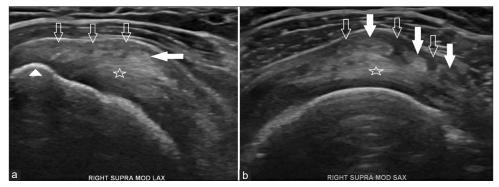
Ultrasound images of the right shoulder. (a) Long-axis and (b) short-axis sonographic images of the same right shoulder, demonstrating heterogeneity and enlargement of the supraspinatus (SUPRA) tendon (stars) with multiple nonshadowing amorphous slightly echogenic to isoechoic foci (solid arrows) within the supraspinatus tendon with partial extension into the adjacent thickened subacromial-subdeltoid bursa (open arrows). The junction between the tendon bursal surface and the bursa itself is ill-defined. The arrowhead points to the greater tuberosity and MOD indicates modified (Crass position)
